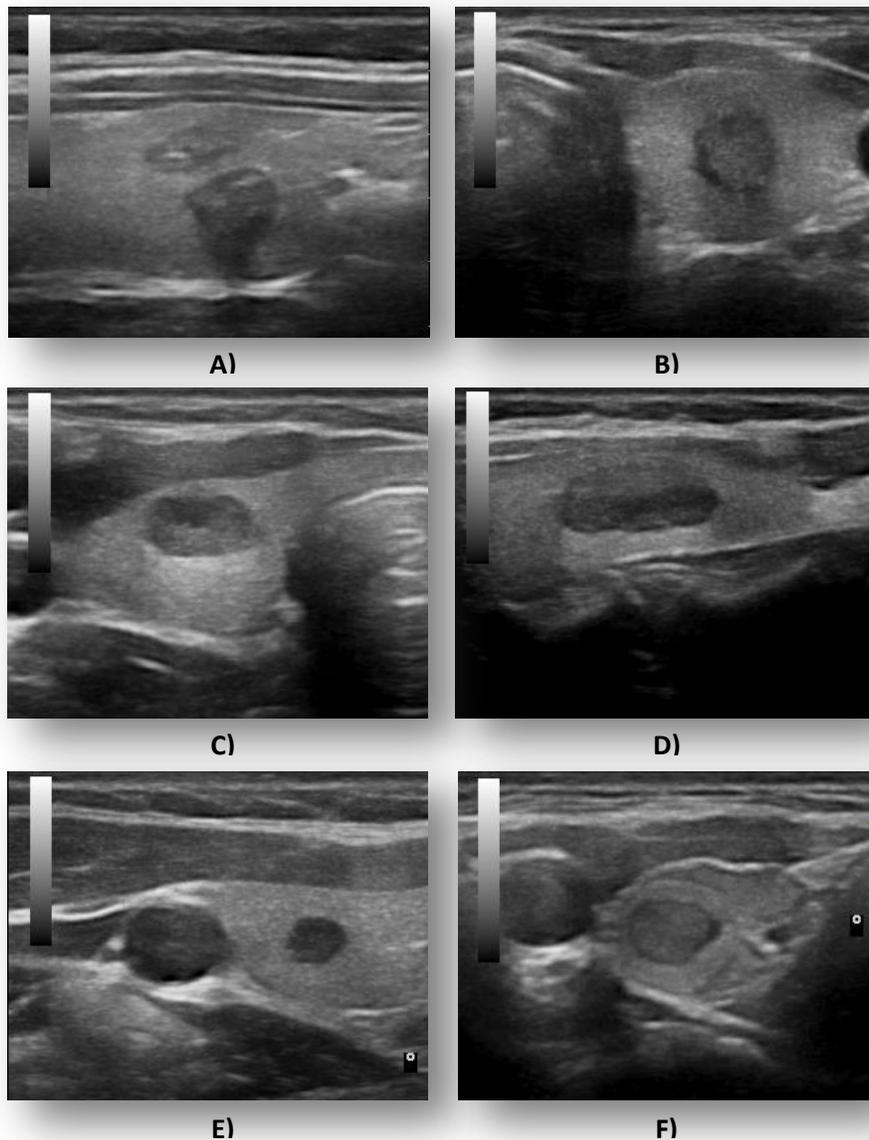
Ultrasound images of selected nodules: A) and B) nodules with posterior acoustic shadowing /papillary cancers/; C) and D) nodules with posterior acoustic enhancement; E) and F) - nodules without posterior acoustic phenomena.
